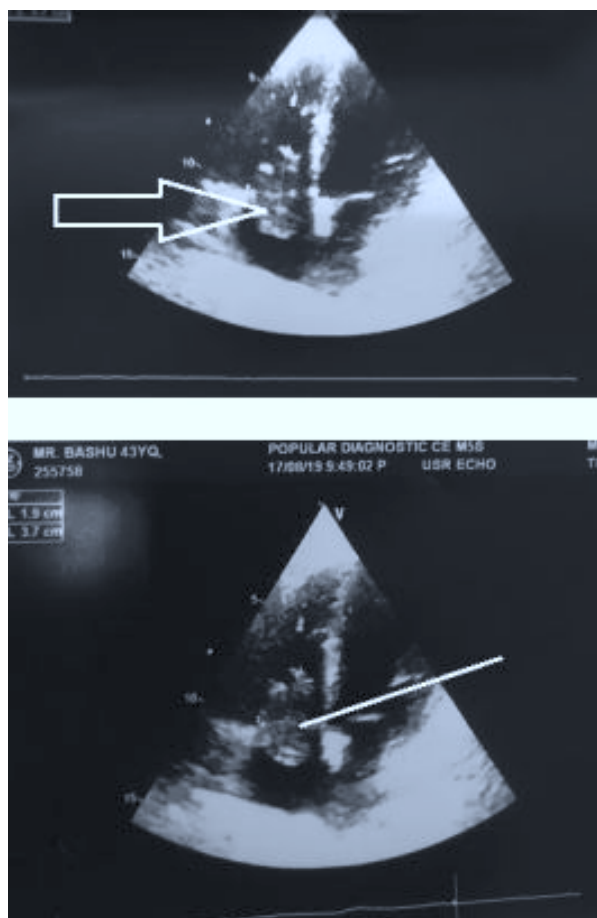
Transthoracic echocardiography showing a echogenic mass (3.7 x 1.9) cm within the right atrium (white arrow and line) extending into right ventricle.
